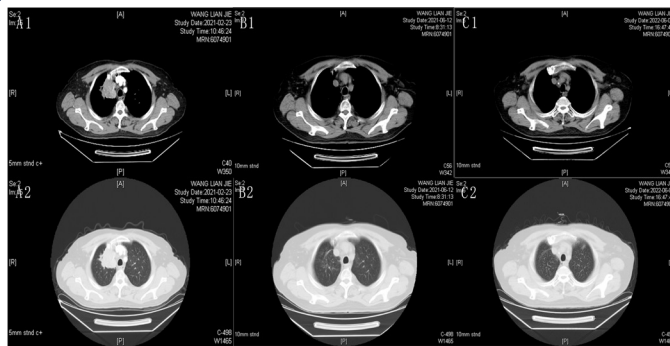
A1&A2, Contrast Computed Tomography images of paramediastinal occupancy in the upper lobe of the right lung. B1&B2, CT images 2 months after PDT. C1&C2, CT images after 14 months after PDT.
